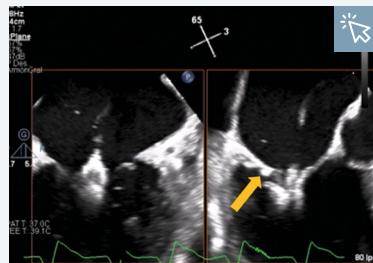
Screening transoesophageal echocardiogram, with the location of the calcium node indicated.²⁷
